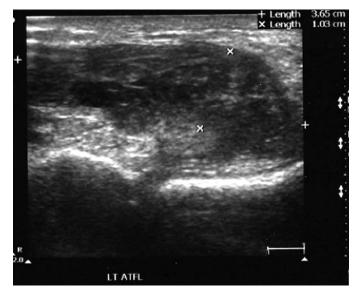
Diagnostic ultrasound of lateral aspect of left ankle. The 2 x's show a large hematoma over the left lateral malleolus and a complete avulsion of AFTL.
